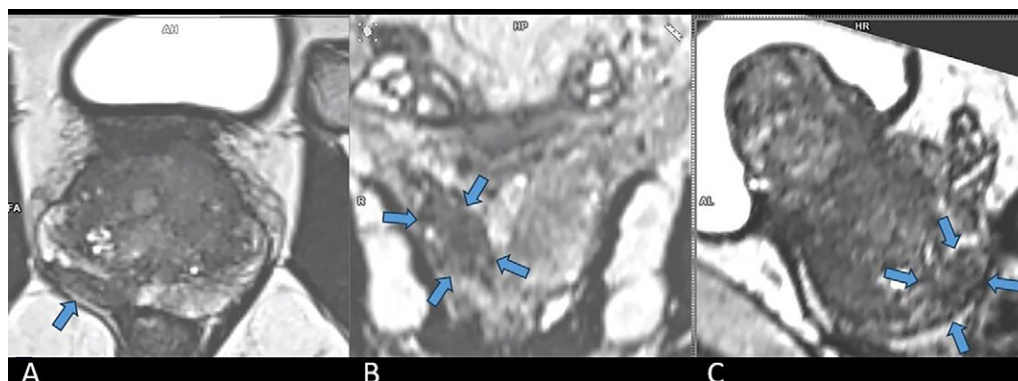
T2-weighted three-dimensional (A) axial, (B) coronal, and (C) sagittal prostate MRI scans in a 74-year-old male participant (initial prostate-specific antigen level, 8 ng/mL). The participant had a confined Prostate Imaging Reporting and Data System 5 lesion (arrows) in the right peripheral zone, with maximum tumor length of 20 mm. A Gleason score 3 + 4 lesion was diagnosed with targeted biopsies, with 10% Gleason score 4 tumor and a cribriform component of 0%. Note that the most medial part of the lesion is in contact with the rectal wall.
